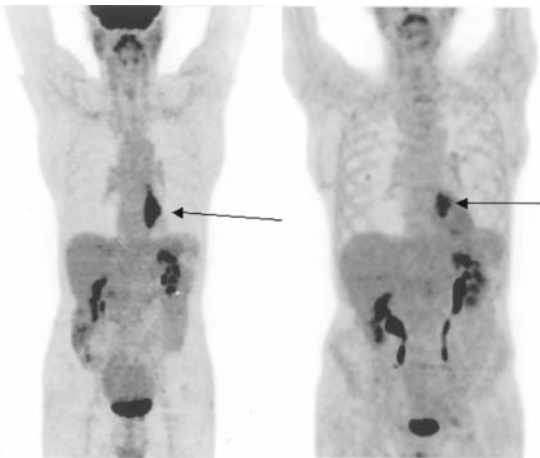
18F-FDG-PET evaluating a patient with esophageal cancer before (left side image) and after (right side image) neoadjuvant chemotherapy. MIP images show primary positive mass (arrows) demonstrating a partial response after therapy (SUV max decreased from 12.6 to 8.4)
